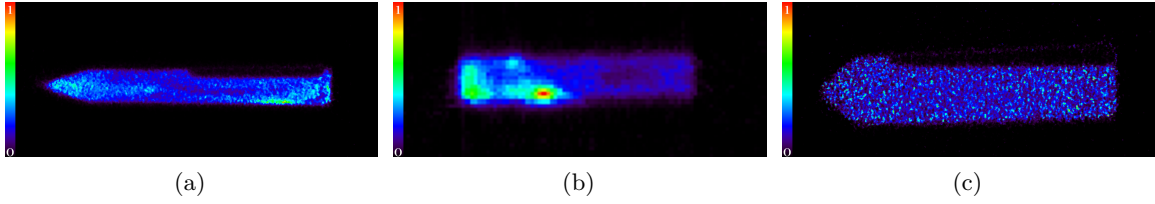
a) Uncured ^{18}F -FDG resin with mixture_{FDG} imaged using the Inveon scanner, b) uncured ^{89}Zr using mixture_{FDG} method imaged using the Inveon scanner, and c) uncured ^{89}Zr using mixture_{Zr} imaged using the MEDISO nanoPET/CT scanner.
